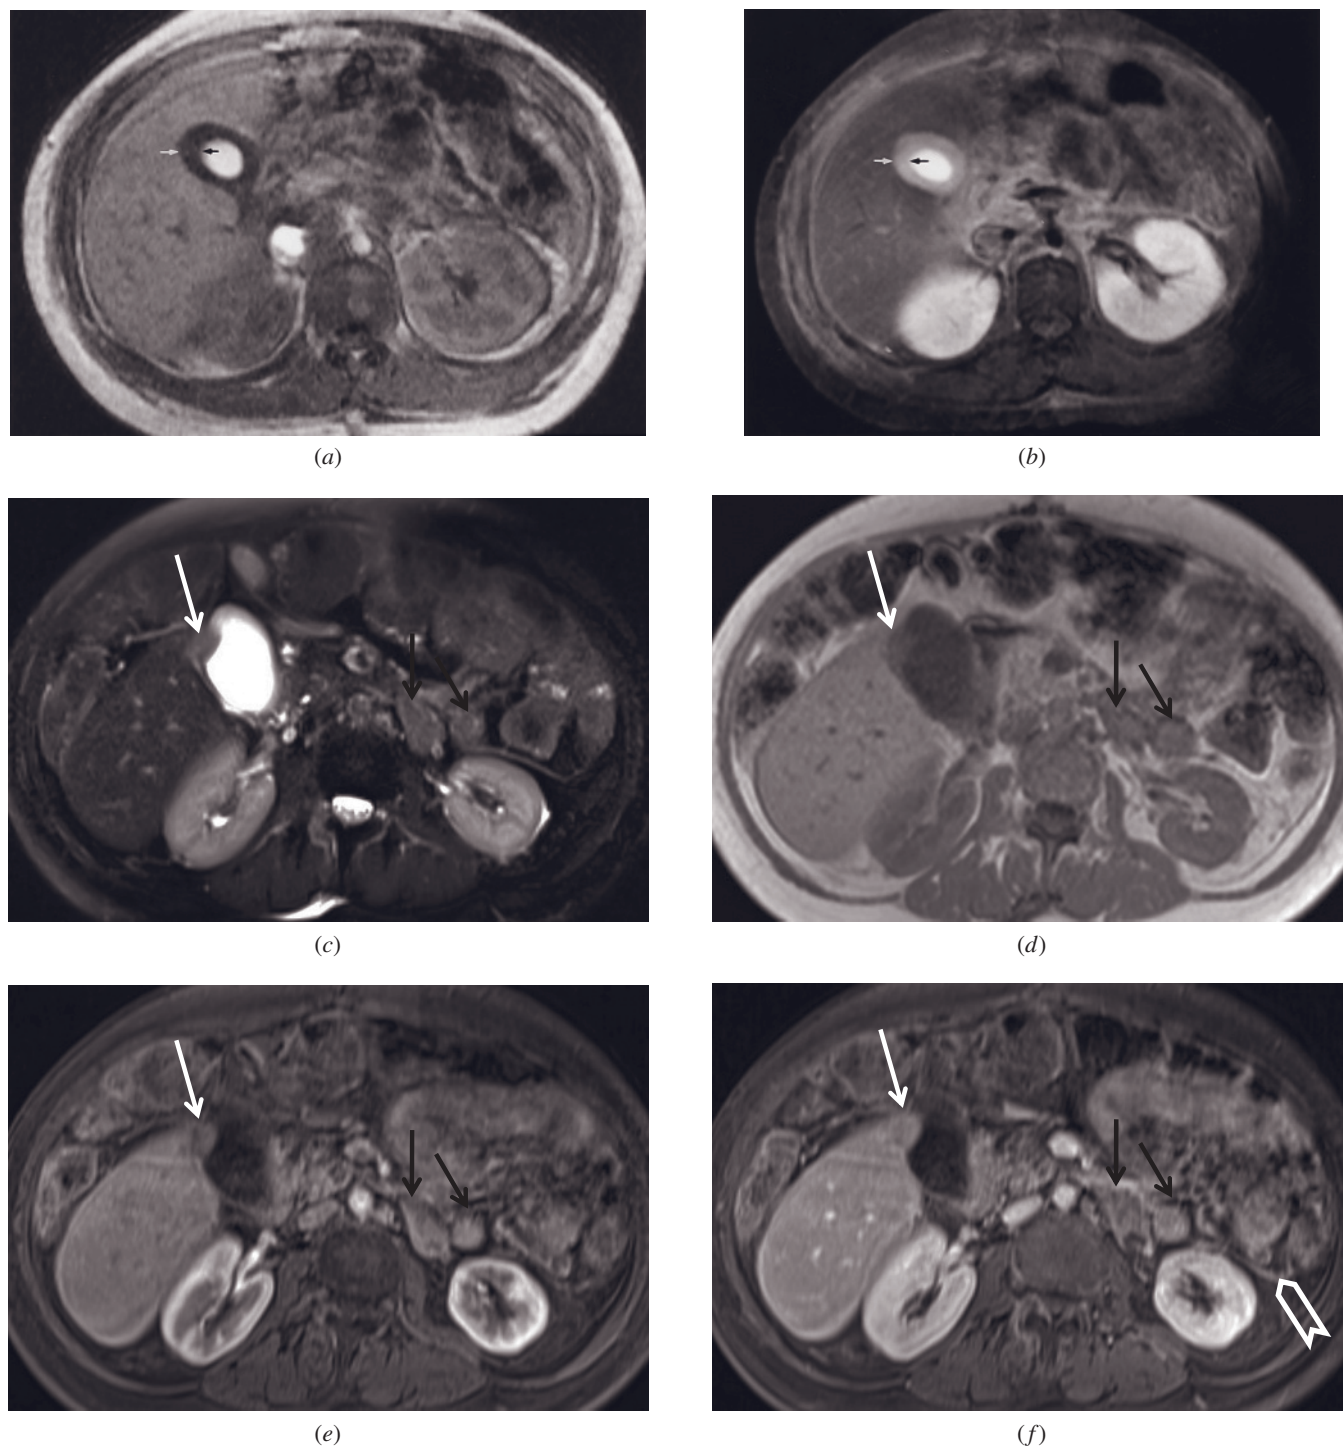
Burkitt lymphoma of the gallbladder. T1-weighted GE (*a*) and 2-min postgadolinium fat-suppressed spin-echo (*b*) images. The gallbladder wall (arrows, *a, b*) is diffusely thickened because of infiltration by lymphoma. Note the uniform moderate enhancement of the wall after contrast administration (*b*), which is less than that observed for acute cholecystitis. Gallbladder metastasis from ovarian cancer. T2-weighted fat-suppressed single-shot echo-train spin-echo (*c*), T1-weighted SGE (*d*), and T1-weighted postgadolinium fat-suppressed hepatic arterial dominant phase (*e*) and interstitial phase (*f*) 3D-GE images demonstrate the gallbladder wall metastases (white arrows, *c-f*) from ovarian cancer. The tumor shows moderate enhancement on postgadolinium images (*e, f*). Note that there are lymph node (black arrows, *c-f*) and peritoneal (open arrow, *f*) metastases.
